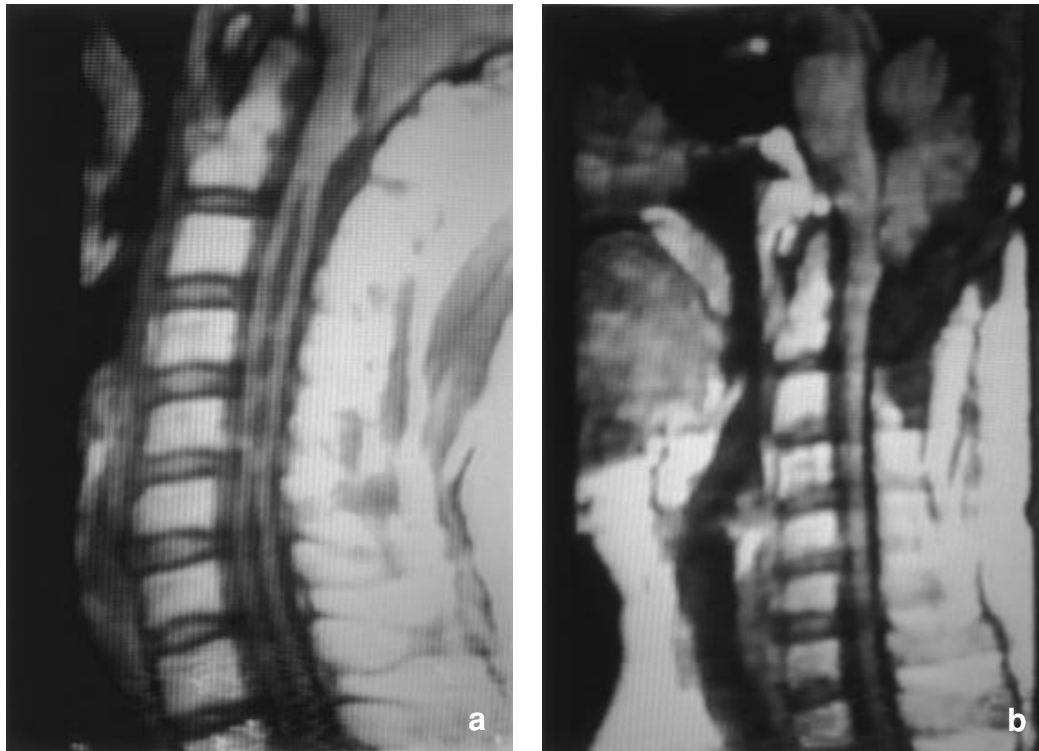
(a) Pre-operative T1-weighted MRI scan in a 60-year-old man. It is visible the presence of a large syringomyelia cavity extending from C1 to C7. (b) Postoperative MRI scan one year from surgical treatment demonstrating the decrease in size of the syrinx
